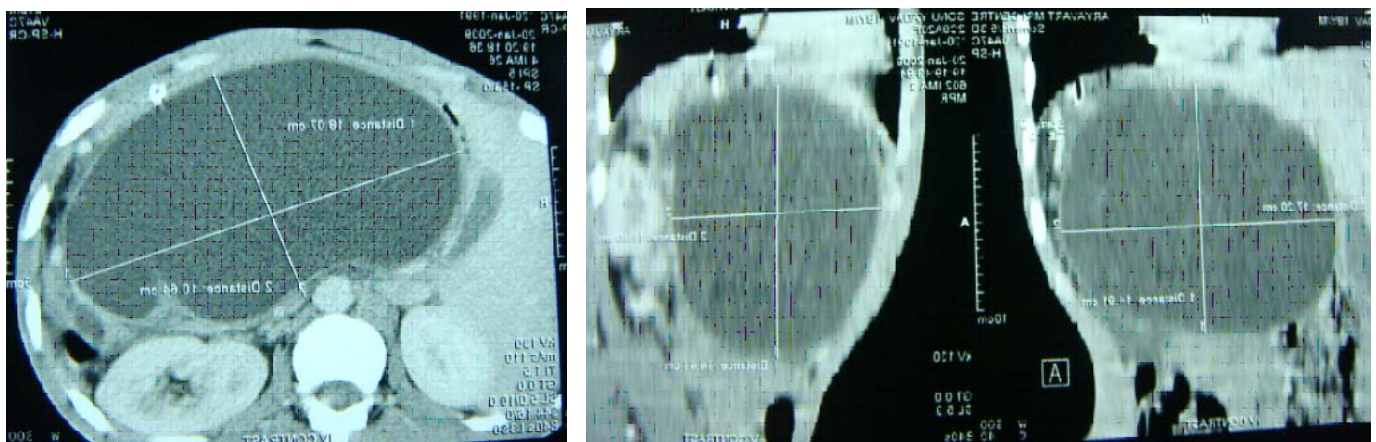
CT scan of the abdomen showing huge pancreatic pseudocyst
